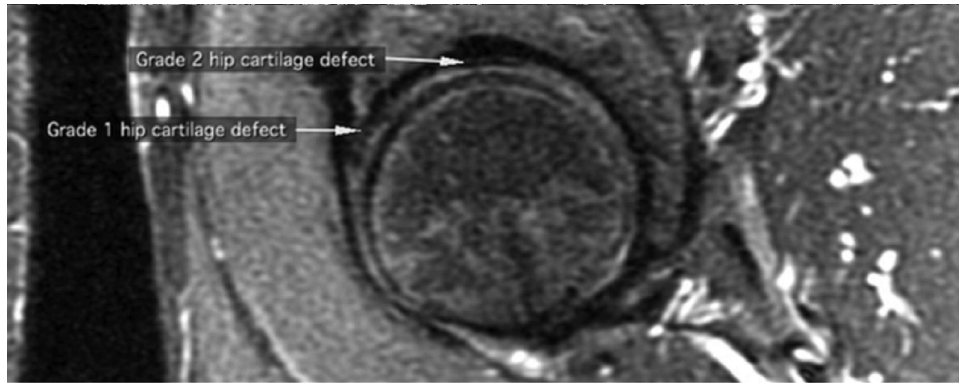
Assessment of grade 1 and grade 2 hip cartilage defects on sagittal short-tau inversion recovery magnetic resonance imaging.
